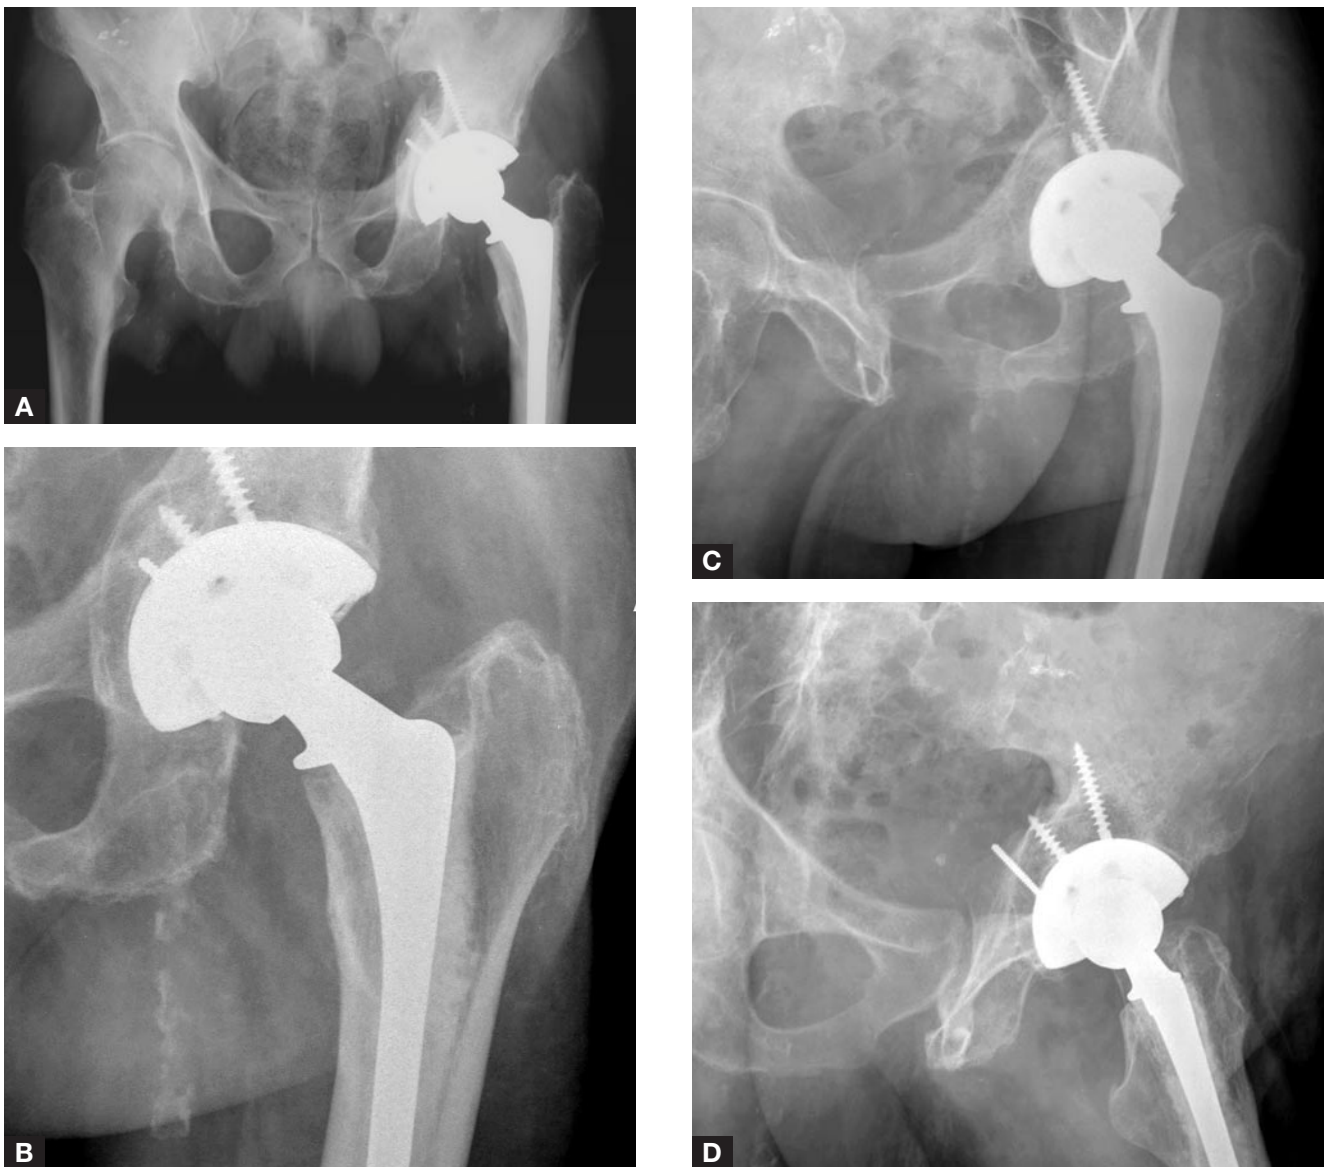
Anteroposterior x-rays obtained 2 months (A) and 26 months (B) after acetabular reconstruction show healing of the acetabular fracture, maintenance of cup and stem position, and no evidence of component loosening or migration. (C,D) Judet x-rays 26 months after acetabular reconstruction show healing of the acetabular fracture.
